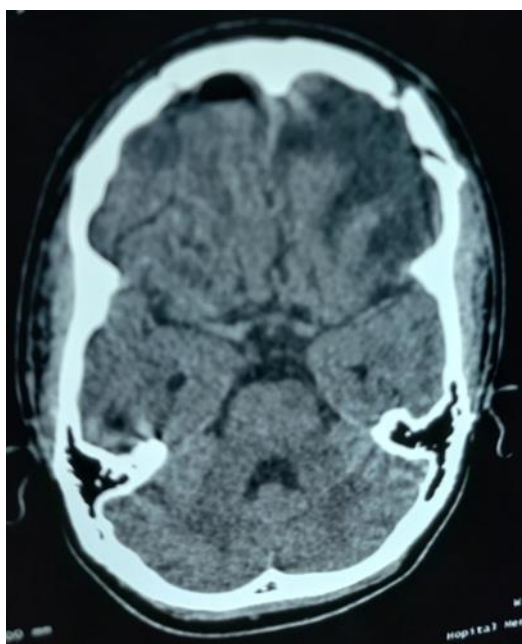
Cerebral CT scan without injection in axial section showing chronic bi-frontal contusion foci opposite the fracture foci with right frontal pneumocephaly
